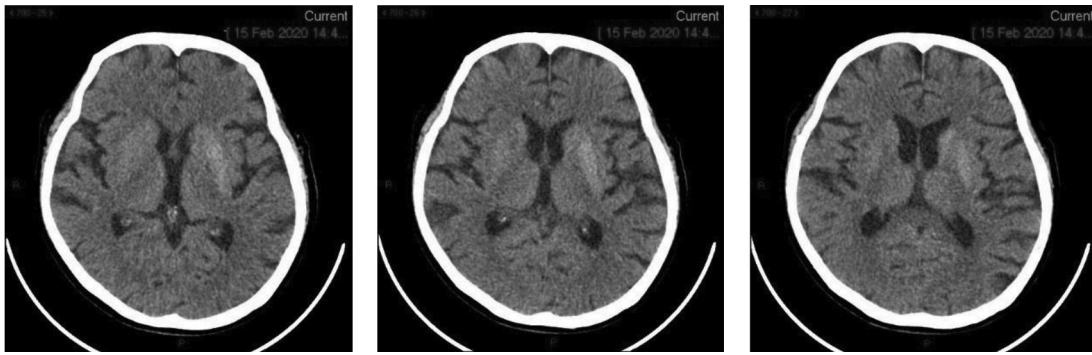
A-C Non-contrast CT scan at first presentation
